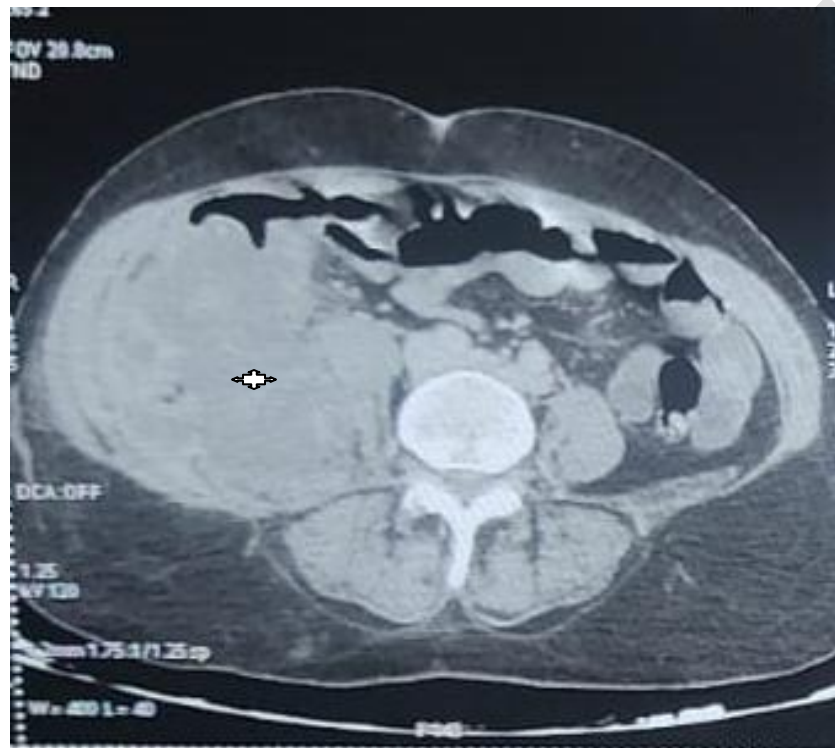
CT appearance of morol process of cecum
